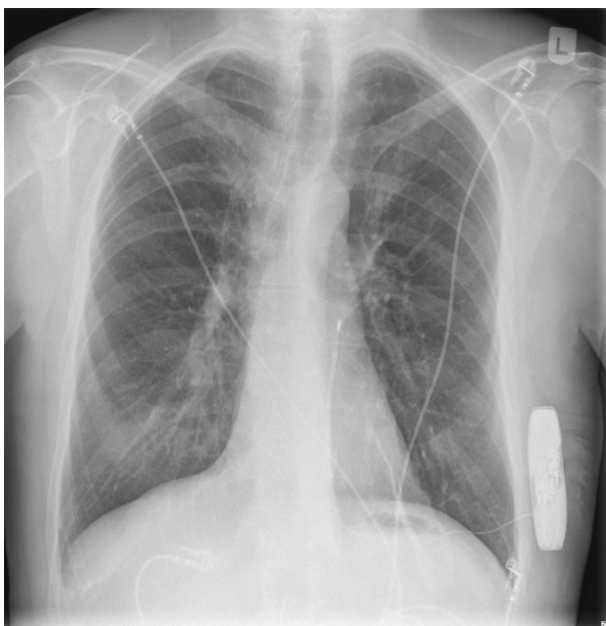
Chest X-ray with the S-ICD in an intermuscular position and the electrode in a parasternal position.
